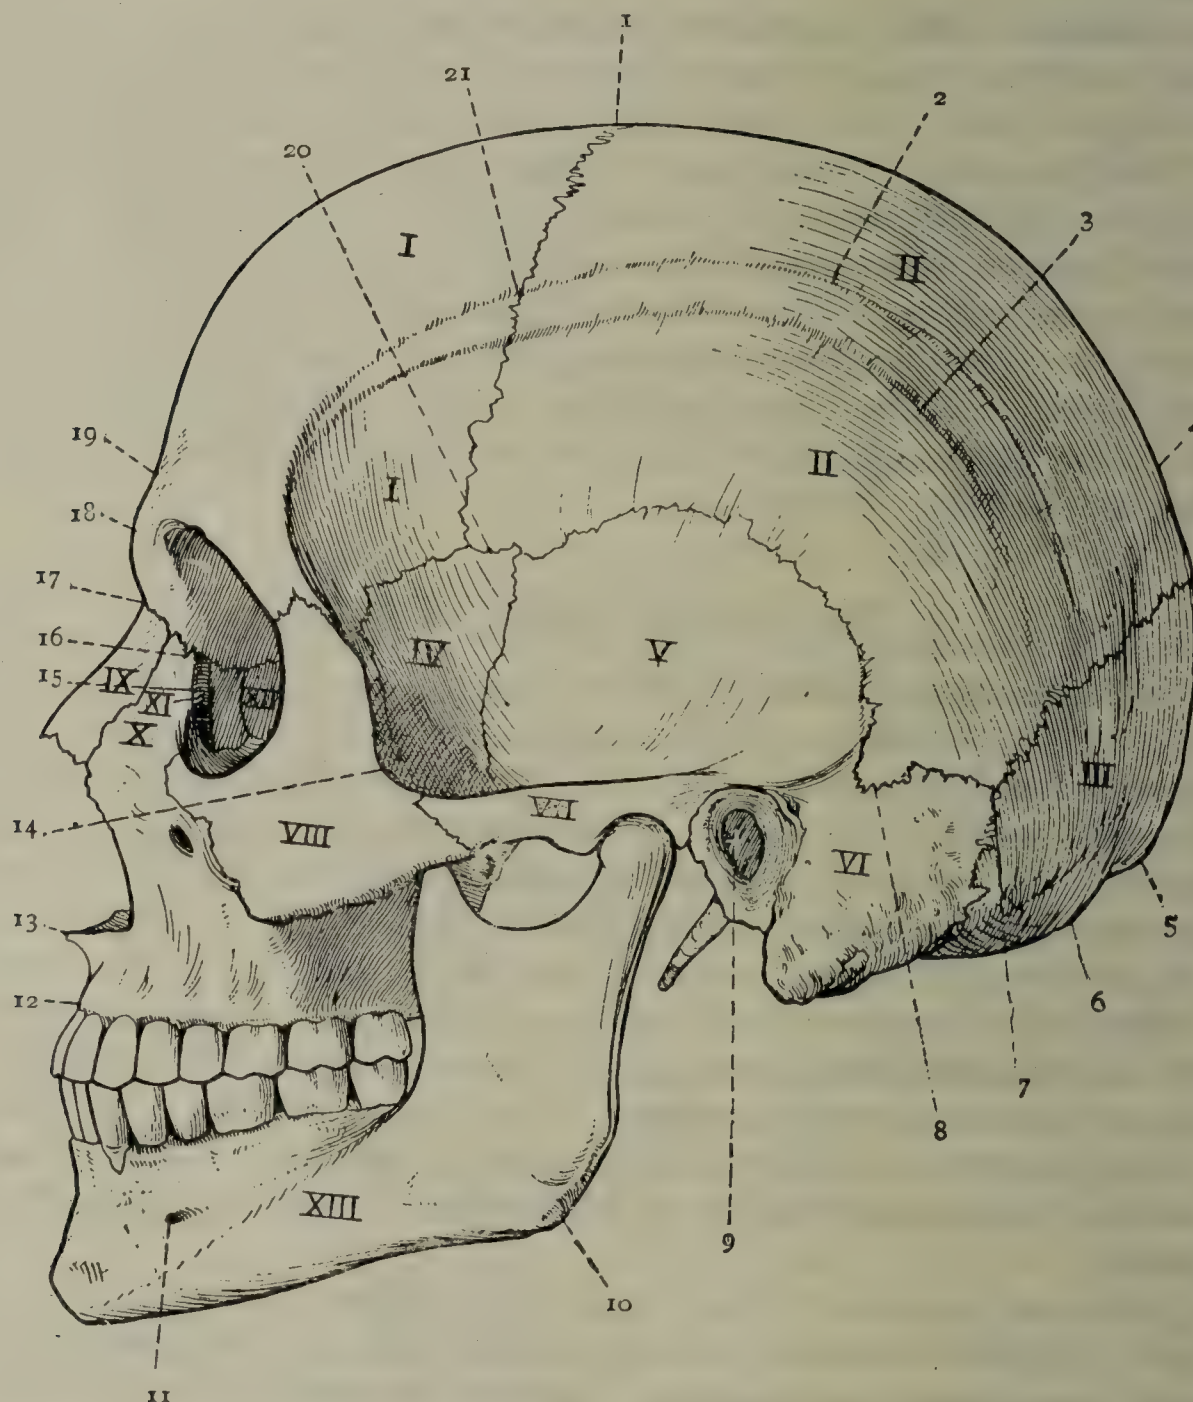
THE LATERAL ASPECT OF THE SKULL (NORMA LATERALIS).
